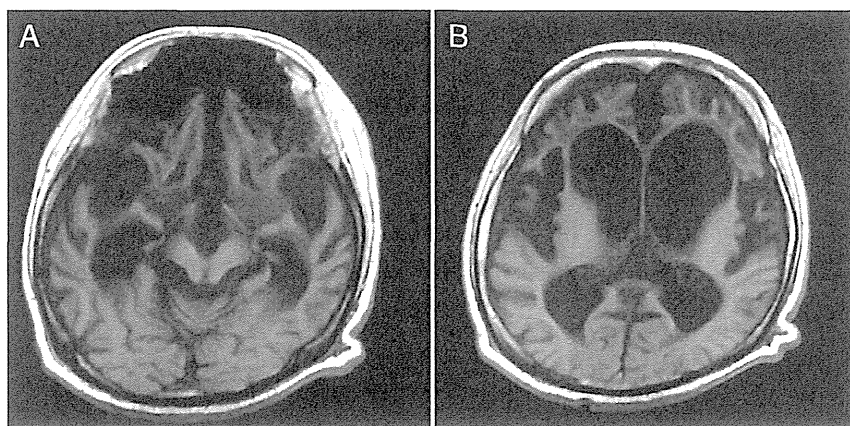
T1-weighted MRI at 31 years of age. (a) Marked atrophy in the brainstem, cerebellum, hippocampus and (a and b) frontotemporal lobes is observed. Note relative sparing of the parietooccipital region compared to the frontotemporal region.
